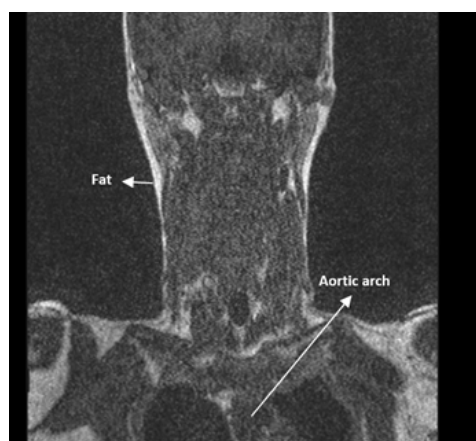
Pre-contrast Mask sequence-3D spoiled gradient. Adapted from: (private MRI clinic, 2018).
